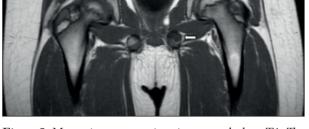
Magnetic resonance imaging coronal plane T1. The lesion is visible as hypointensity signal (white arrow)
